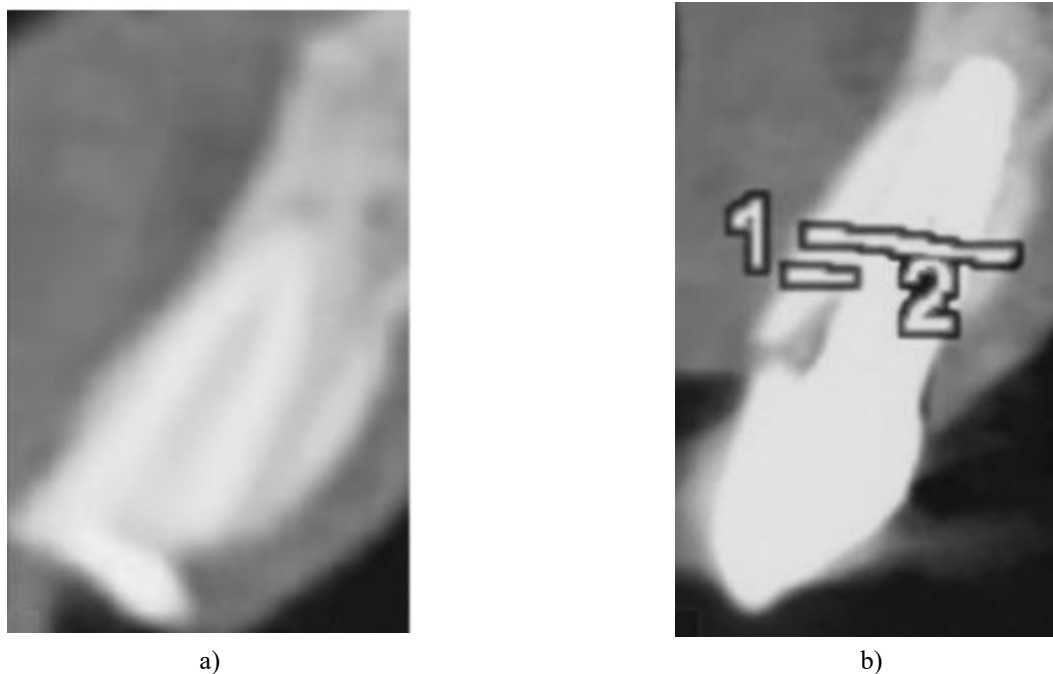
(a and b) Postoperative computed tomography showing increased bone thickness buccal to implant after 2 years
